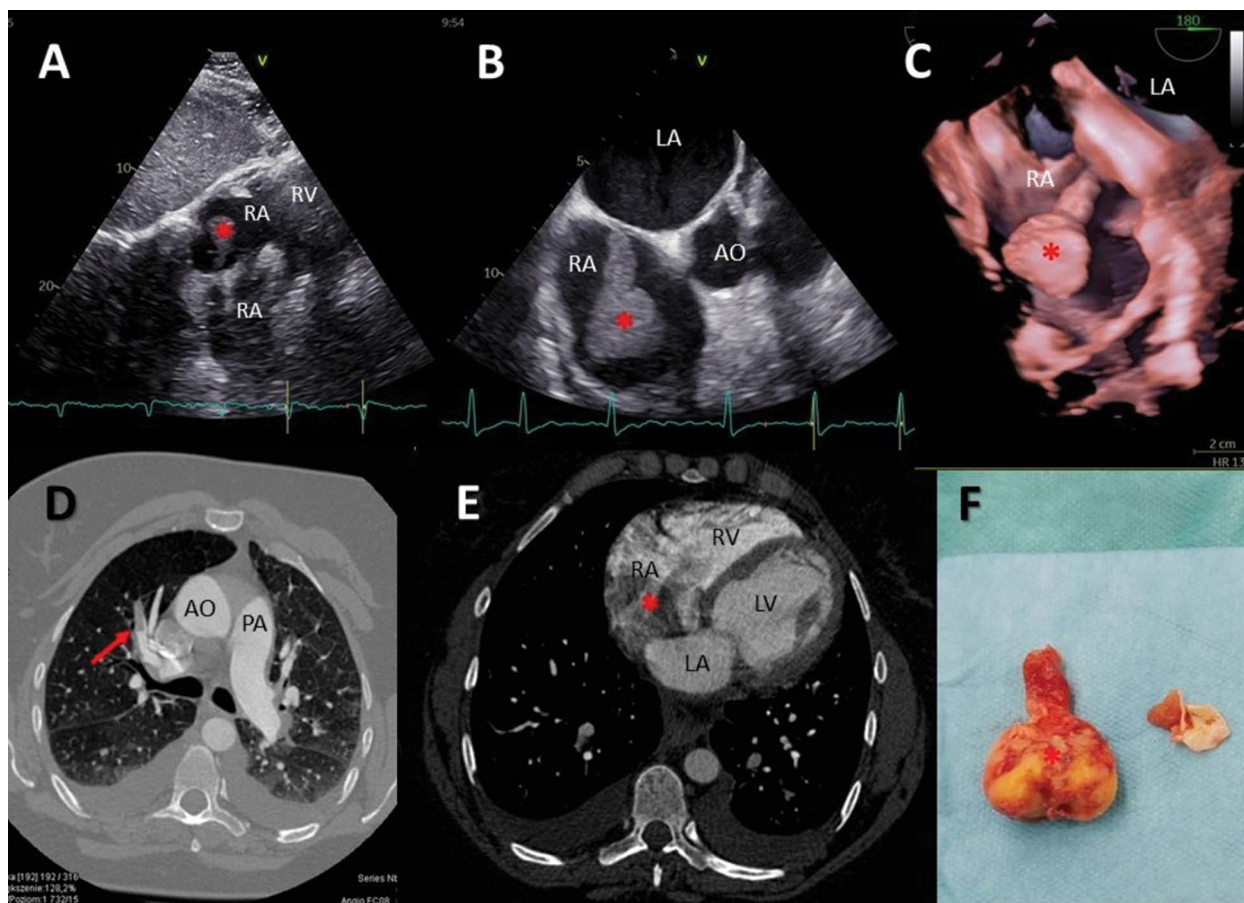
Transthoracic echocardiography – substernal view; B. Transoesophageal echocardiography – high transoesophageal view, 2D greyscale imaging, an asterisk indicates the right atrial pedunculated tumour in the fossa ovalis region of the interatrial septum; C. 3D echocardiography – volumetric mapping, an asterisk indicates the right atrial pedunculated tumour in the fossa ovalis region of the interatrial septum; D. Computed tomography of the pulmonary arteries, an arrow indicates embolic material in the segmental arteries of the right lung; E. Cardiac computed tomography, an asterisk indicates right atrial tumour – motion artefacts present; F. Intraoperative image – the resected right atrial tumour (marked with an asterisk) and part of the interatrial septum; LA – left atrium; LV – left ventricle; PA – pulmonary artery; RA – right atrium; RV – right ventricle
